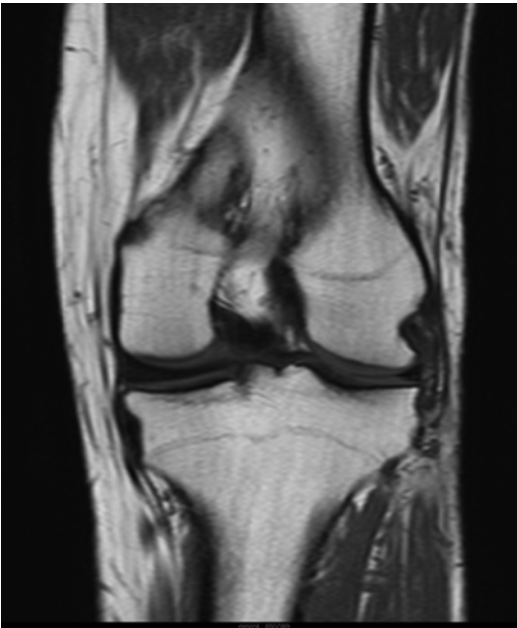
Coronal magnetic resonance image of the patient
